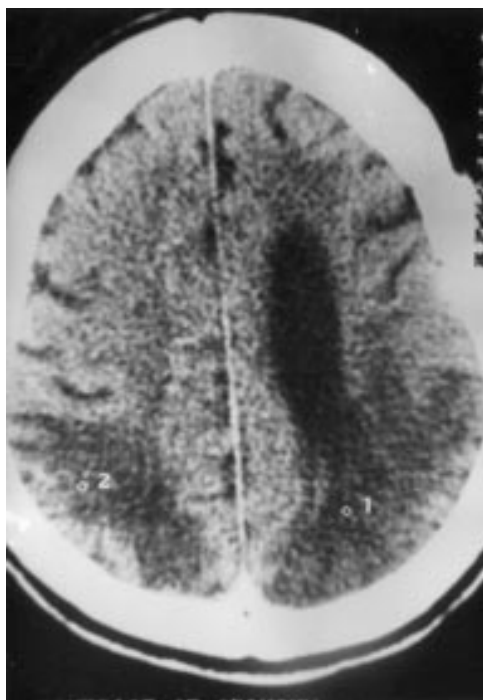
Cranial computed tomography showing bilateral posterior leukoencephalopathy in the patient described in box 4.
